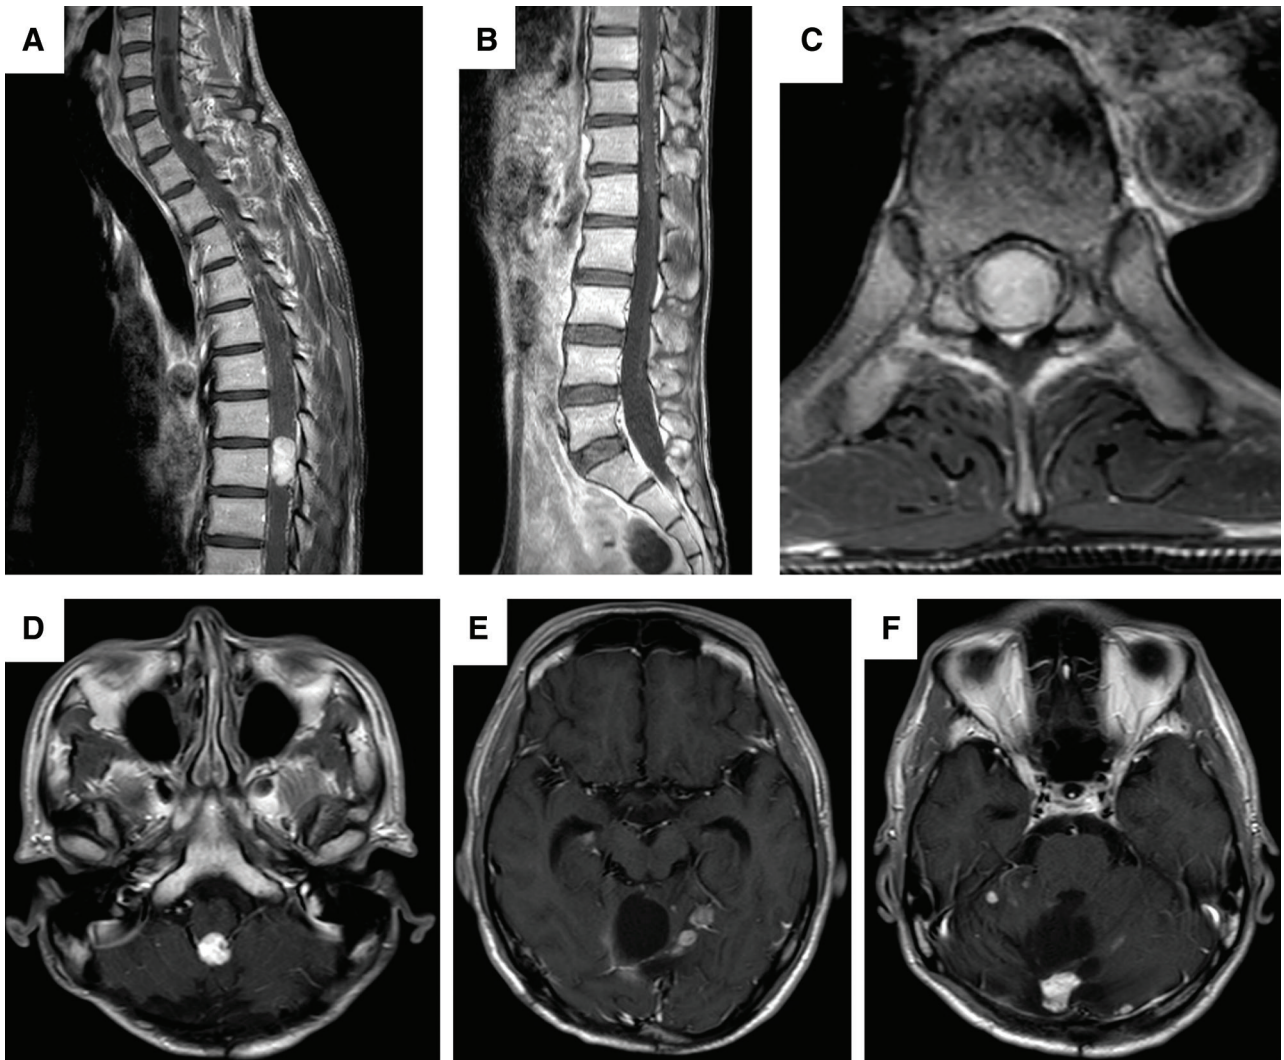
Preoperative MRI scan. Gd-enhanced spinal MRI revealing that tumors with syrinx are located at the C7 and Th8. Sagittal image of the (A) cervicothoracic and (B) lumbar region. (C) An axial image of Th8. (D–F) Gd-enhanced brain MRI demonstrating tumors in the cerebellar hemisphere and close to the medulla oblongata. Gd: gadolinium, MRI: magnetic resonance imaging.
